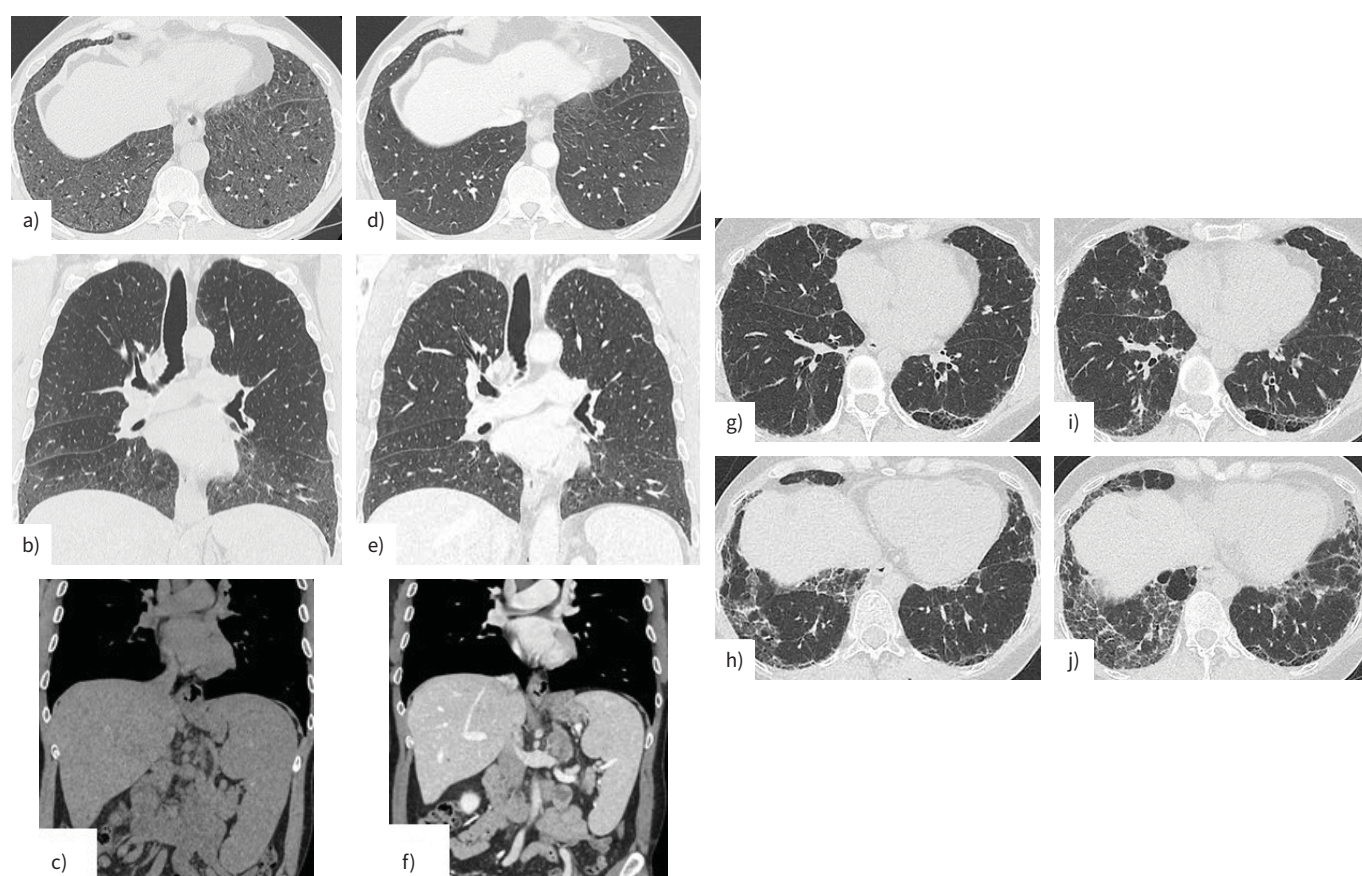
Computed tomography (CT) patterns associated with acid sphingomyelinase deficiency (ASMD) and Hermansky–Pudlak syndrome. a, b and c 58-year-old man with interstitial lung disease (ILD) and splenomegaly secondary to ASMD. The chest CT shows basal predominant ground-glass opacities with limited superimposed septal lines in addition to a large splenomegaly and mild hepatomegaly. After 1 year with olipudase therapy, the ILD dramatically improved (d and e) and the volume of both spleen and liver decreased (f). This correlated with the pulmonary function test results and symptoms. g, h The diagnosis of Hermansky–Pudlak syndrome with ILD was established in a 51-year-old woman presenting with a history of spontaneous bleeding and albinism. Chest CT scan, indeterminate for usual interstitial pneumonia, showed subpleural predominant reticular and ground-glass opacities, with some peribronchovascular distributed opacities. Honeycombing was also present. i, j After 2 years follow-up, the patient exhibited clinical functional and radiological progression of pulmonary fibrosis but has so far declined any antifibrotic therapy.
